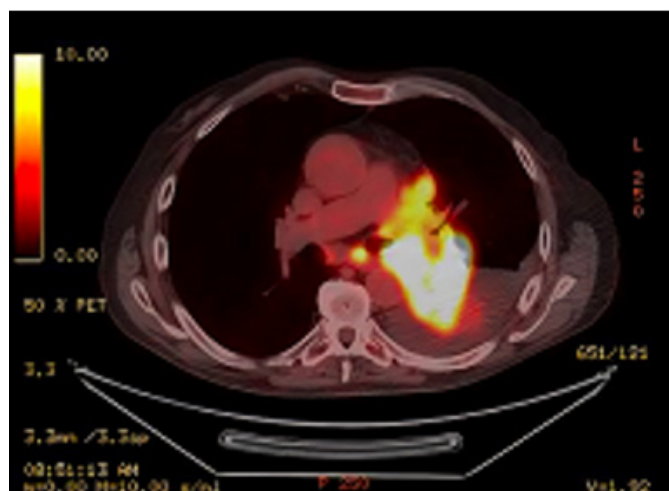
PET scan showing a  $12.1 \times 7.3 \times 8.4$  cm highly avid central, infra-hilar left lower lobe mass, obliterating the left lower lobar bronchus with an  $\text{SUV}_{\text{max}}$  of 20.6, with a  $15 \times 12$  mm FDG avid ( $\text{SUV}_{\text{max}}$  11.1) subcarinal lymph node and a moderate left sided pleural effusion demonstrating low activity with a  $\text{SUV}_{\text{max}}$  of 1.7.
